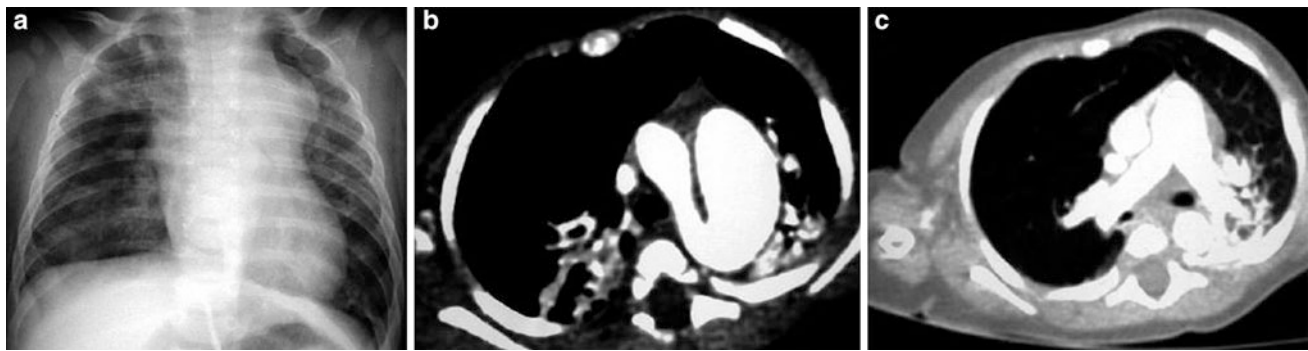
Patent ductus arteriosus in a 3-month-old girl with pulmonary hypertension. a Chest X-ray shows right pulmonary hyperinflation and a bulge in the left upper cardiac silhouette. b CT demonstrates that it
